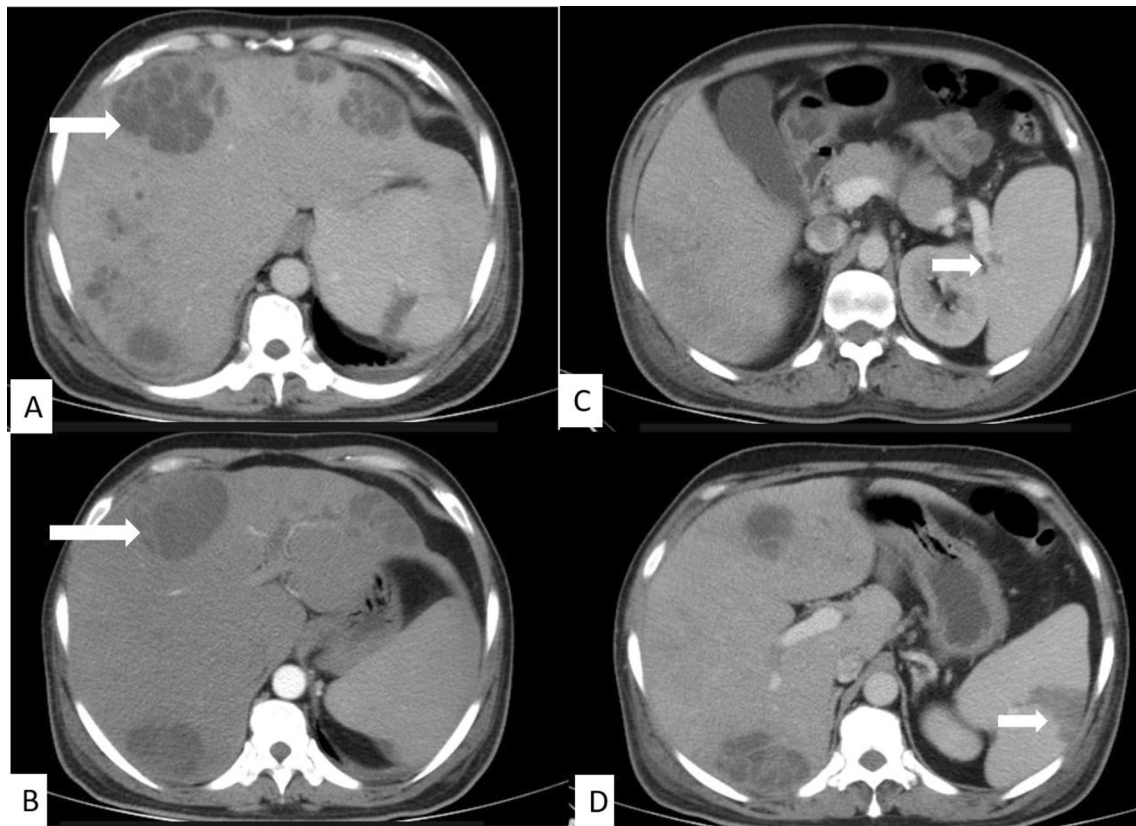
Contrast-enhanced CT of the abdomen—venous A and arterial B phase axial images showing multiple peripherally enhancing hypodense lesions with internal septations giving honeycomb appearance in the liver (arrows). Venous phase axial images C & D show a filling defect (thrombus) in splenic vein at the splenic hilum (small arrow) and a wedge-shaped peripheral non-enhancing hypodense lesion in spleen suggestive of splenic infarct (small arrow)
